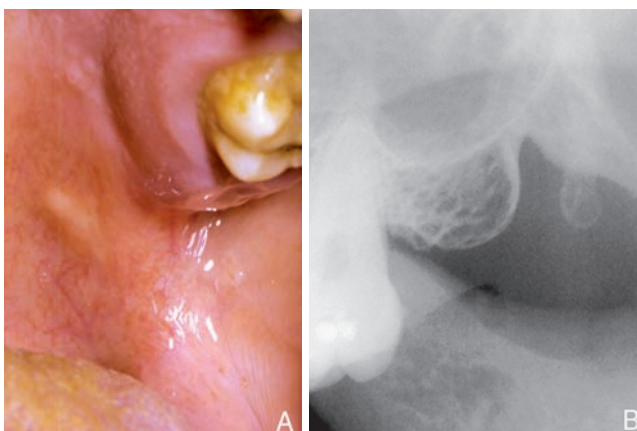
Maxilla: Clinical photograph (A) and radiograph (B) of tuberosity region.
